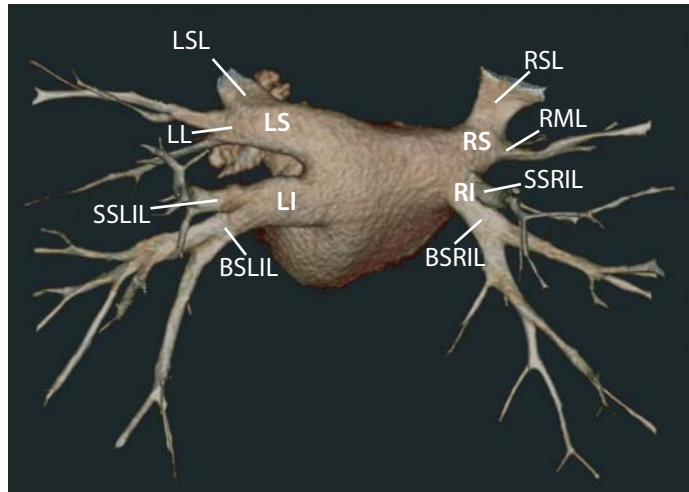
Dorsal cranial view of the left atrium and pulmonary veins reconstructed from a data set obtained with 16-slice CT using 16×0.75 -mm collimation. *L/RS* Left/right superior, *L/RI* left/right inferior, *LL* left lingula, *RML* right middle lobe, *L/RSL* left/right superior lobe, *SSLIL/SSRIL* superior segment of left/right inferior lobe, *BSL/BSRIL* basilar segment of left/right inferior lobe
